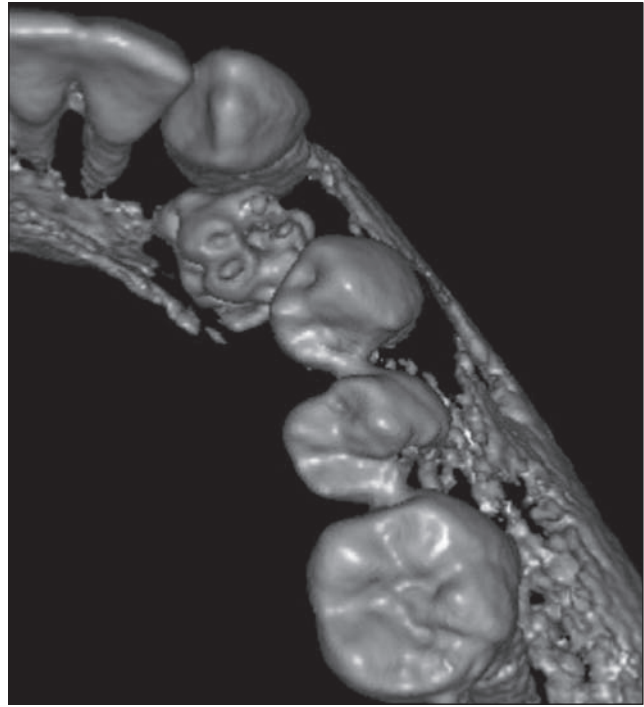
CBCT scan (patient J.B.).
